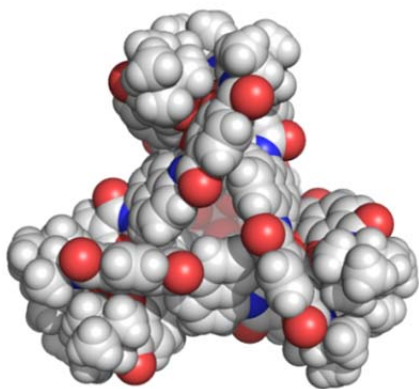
X-ray structure of $\Delta\Delta\Delta\Delta-6$.
